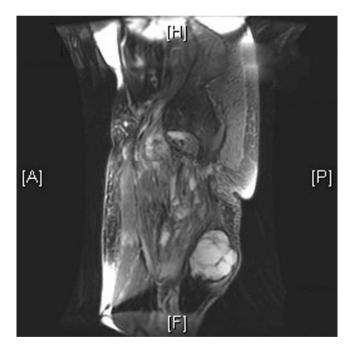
T1-weighted MRI image of a left thigh extraskeletal osteosarcoma
